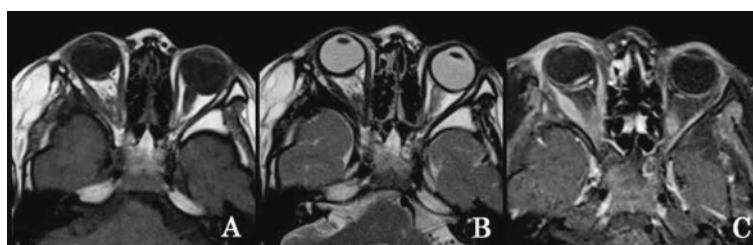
Follow-up magnetic resonance imaging (MRI) scans 5 years after surgery
